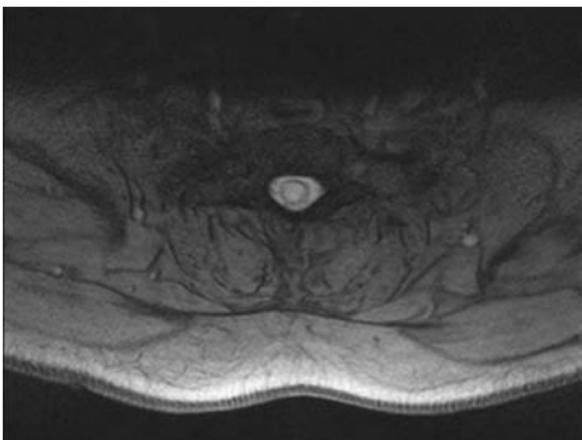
Syringomyelia. (a) Sagittal T2W and (b) axial T2W MRI. A multisep-tated centrally located intramedullary long segment lesion of CSF signal intensity on both T2W and T1W imaging expands the spinal cord and extends into the inferior brainstem as syringobulbia ((a) white arrow).
